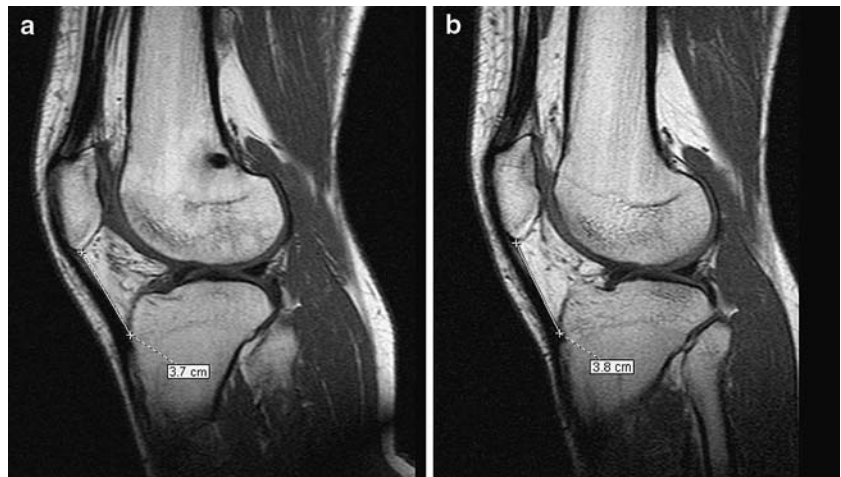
a Measurement of the patellar tendon length in a sagittal MRI of a knee 14 months after ACL reconstruction with HS graft. b Sagittal MRI of the contralateral healthy knee (1 mm difference or 2.6%)
